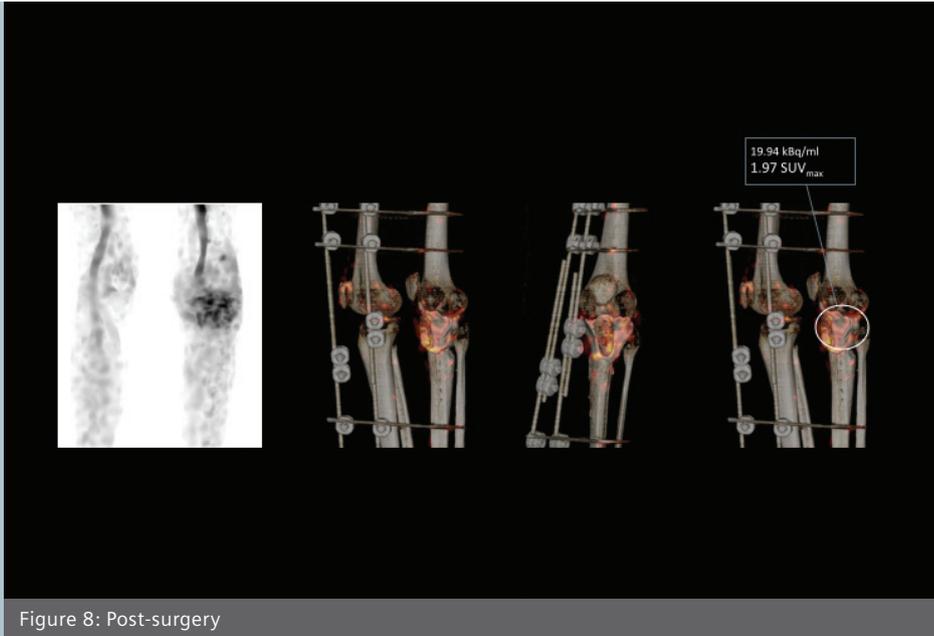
Follow-up SPECT/CT infection imaging with ^{99m}Tc anti-granulocyte antibodies with SUV quantification using xSPECT quant.
